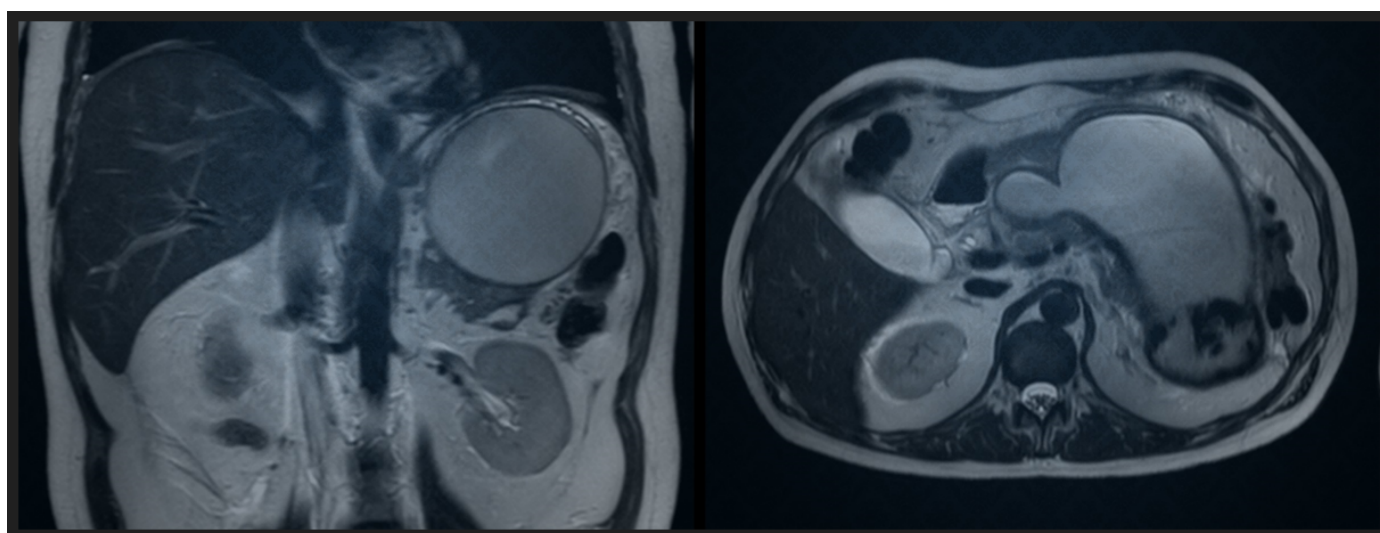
MRI examination from February 2017
